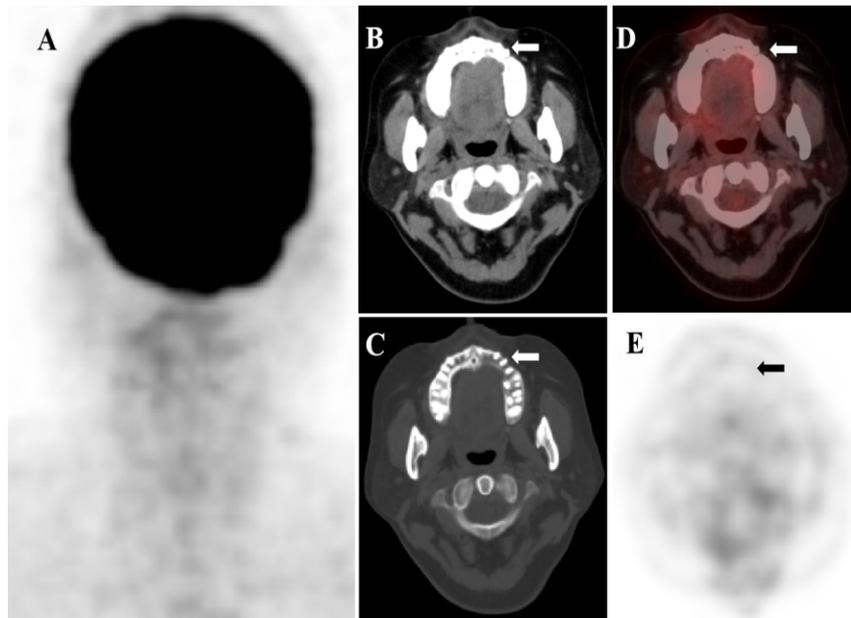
Positron emission tomography/CT imaging after three cycles of chemotherapy. Positron emission tomography/CT imaging after chemotherapy showed there is no obvious tumor lesion on MIP imaging (A), soft tissue window (B) and bone window (C) in axial CT, PET/CT fusion imaging (D) and PET imaging (E), respectively.
